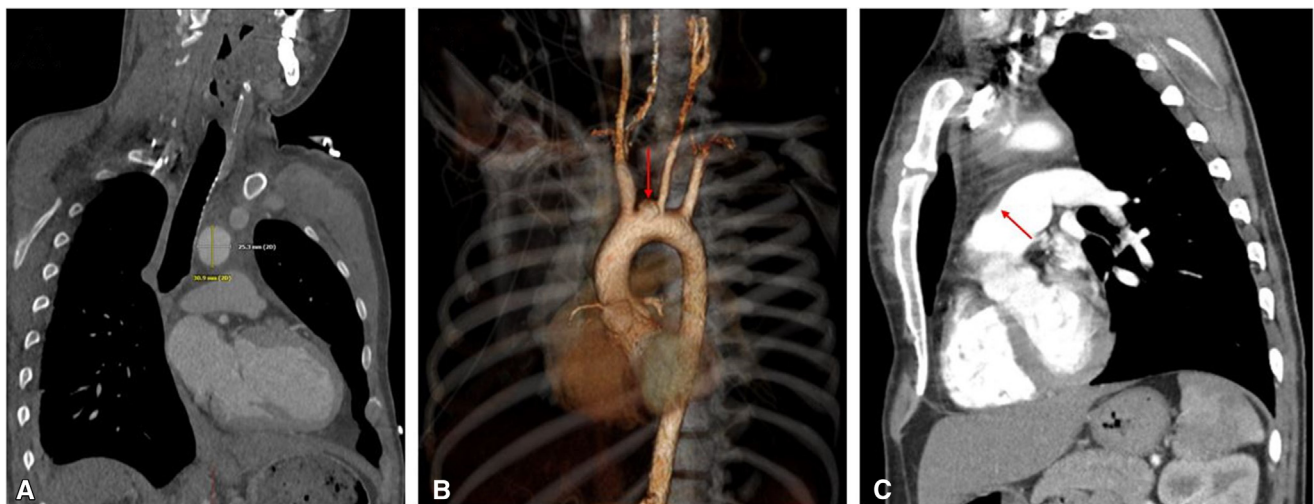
Repeat computed tomography angiography measurements (A) and 3-dimensional reconstructions (B) red arrow is demonstrating the ascending aortic pseudoaneurysm and the presence of the intramural hematoma (C).
